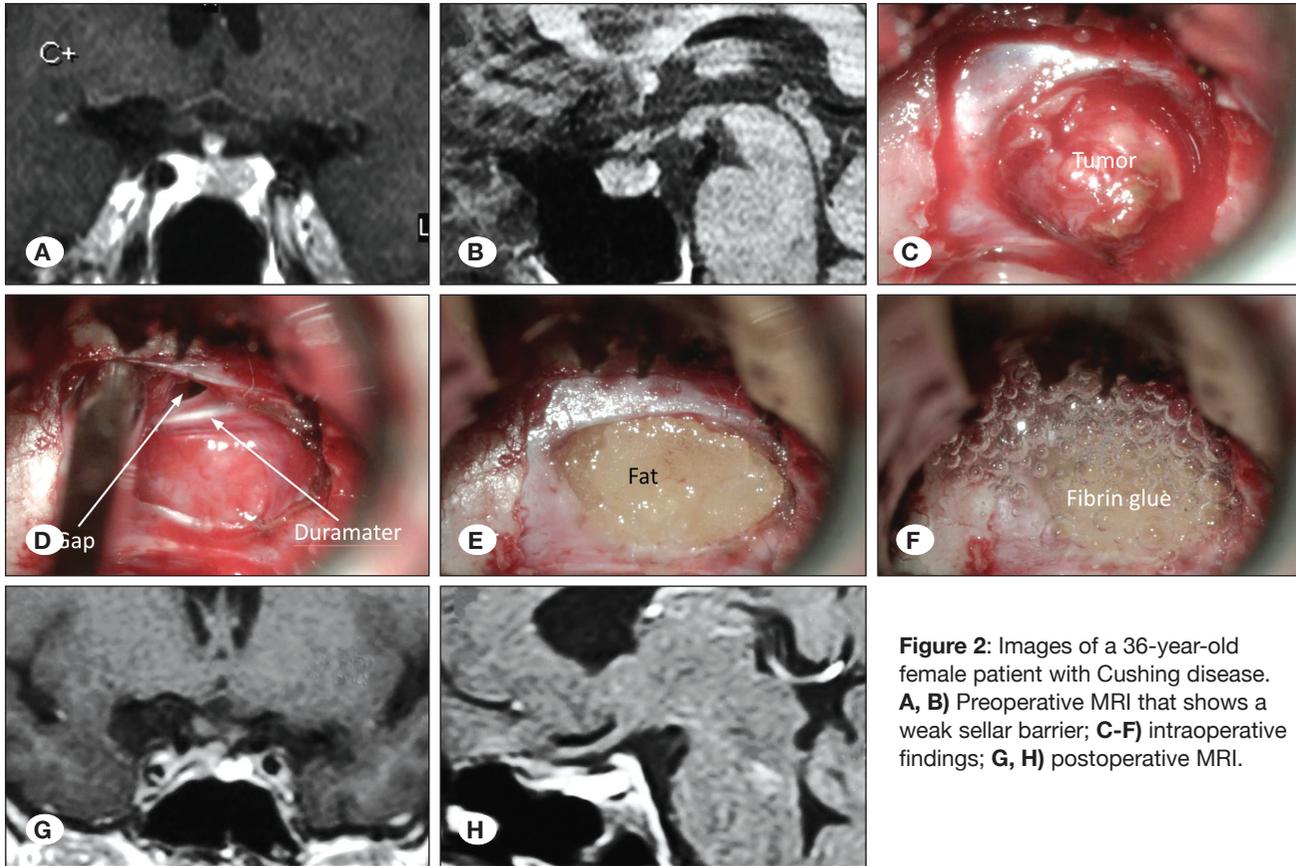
Images of a 36-year-old female patient with Cushing disease. A, B) Preoperative MRI that shows a weak sellar barrier; C-F) intraoperative findings; G, H) postoperative MRI.
